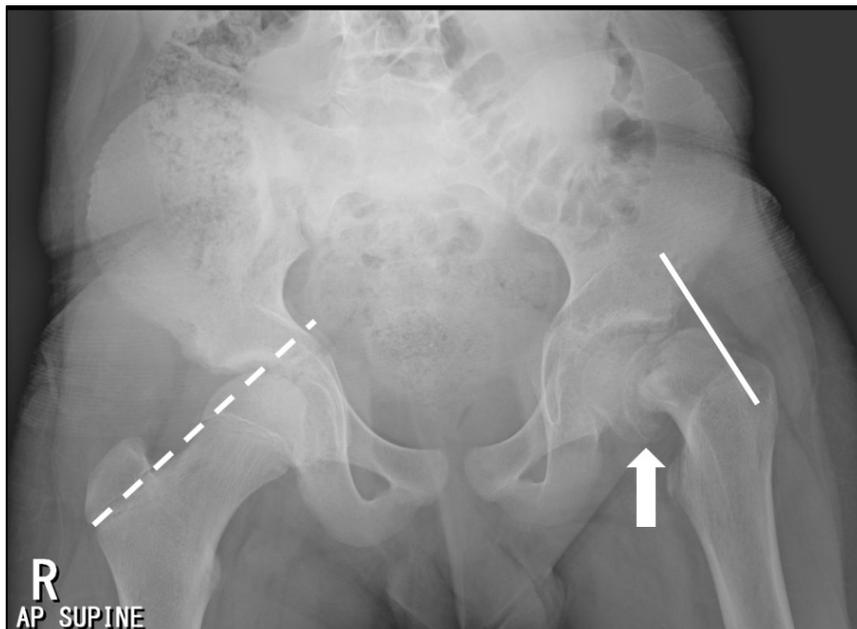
Hip radiography showing posteromedial slippage of the left femoral epiphysis. There is posteromedial slippage of the left femoral epiphysis (white arrow). The Klein's line which is a line drawn through the lateral aspect of the left femoral neck does not bisect the femoral epiphysis (also called Trethowan's sign). Compare with normal finding on right side (dotted line).
